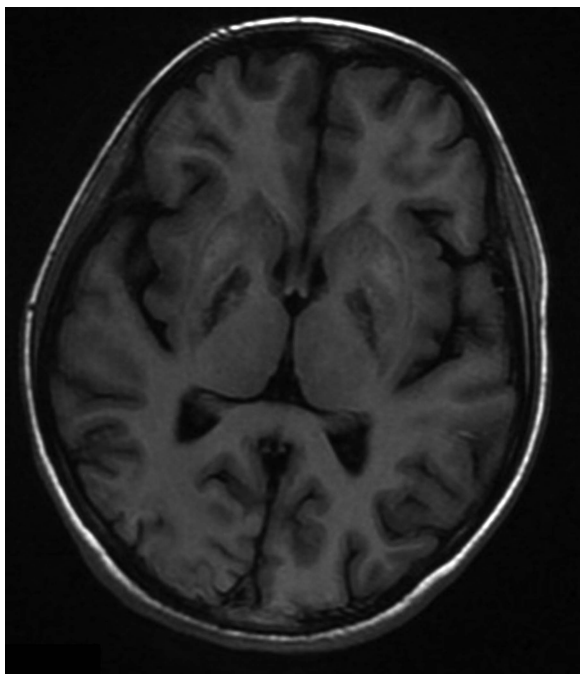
T1-weighted sequence showing hypointense lesion in bilateral basal ganglia.
